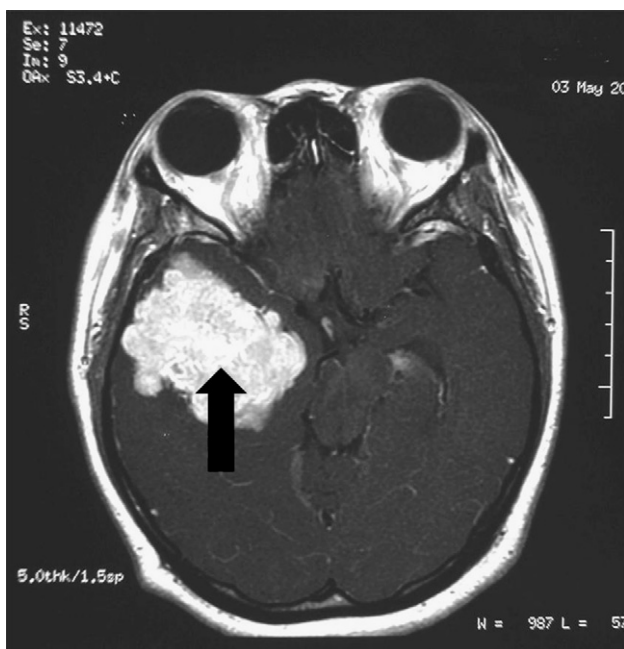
MRI of intracranial mesenchymal chondrosarcoma. The tumor is strongly enhanced with contrast (arrow).
